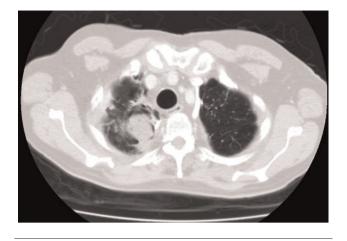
A chest CT scan demonstrating a cavitating lesion in the right upper lobe and pleural thickening.
